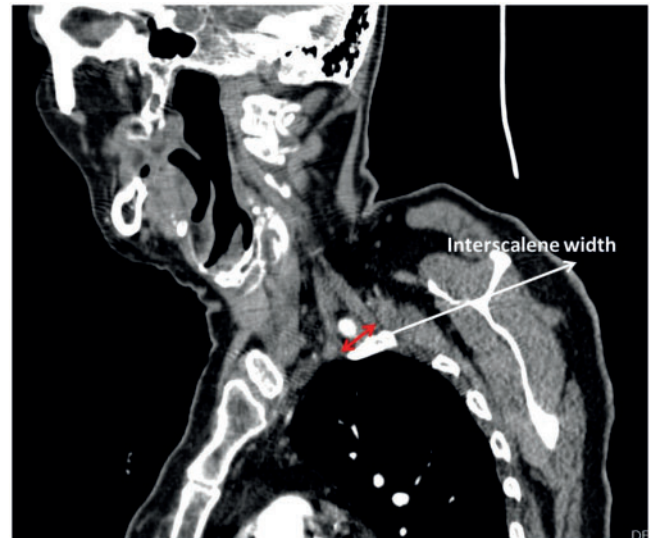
Computed tomography angiography showing the interscalene space width.
